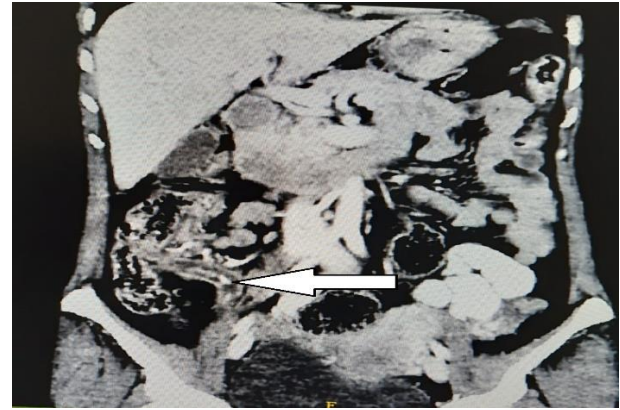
CT abdomen showing inflamed appendix with faecolith inside.
